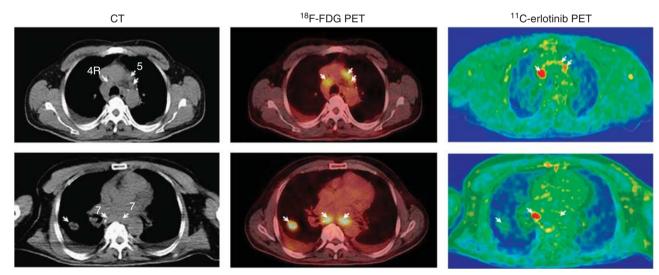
¹¹C-erlotinib PET/CT demonstrates the heterogeneous nature of advanced lung cancer. Two transaxial slices of (left) contrast-enhanced CT; (middle) ¹⁸F-FDG PET/low-dose CT, and (right) ¹¹C-erlotinib PET/low-dose CT. A 48-year-old patient (no. 7) with NSCLC in the right lung and enlarged mediastinal lymph nodes (upper and lower panel left figure, arrows). Both ¹⁸F-FDG and ¹¹C-erlotinib accumulated in lymph nodes at positions 4R and 5 (upper panel, arrows). The tumour in the right lung and one of the lymph nodes at position 7 showed only a weak accumulation of ¹¹C-erlotinib (arrows). The ratio between the ¹¹C-erlotinib average radioactivity concentrations in the lymph node metastasis and that in surrounding lung tissue was 2 (see Figure 4).
